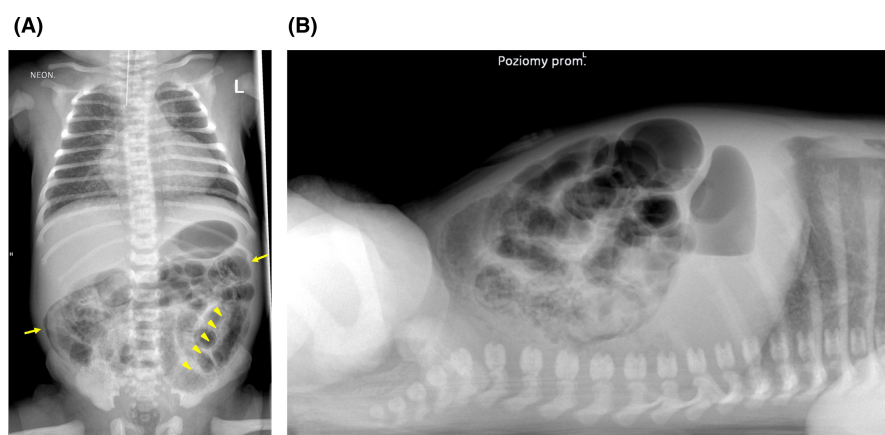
(A) X-ray of chest and abdomen reveals distended large bowel (arrows) with pneumatosis intestinalis (arrowheads). (B) There is no free peritoneal gas—assessed on lateral projection taken with horizontal beam technique.
